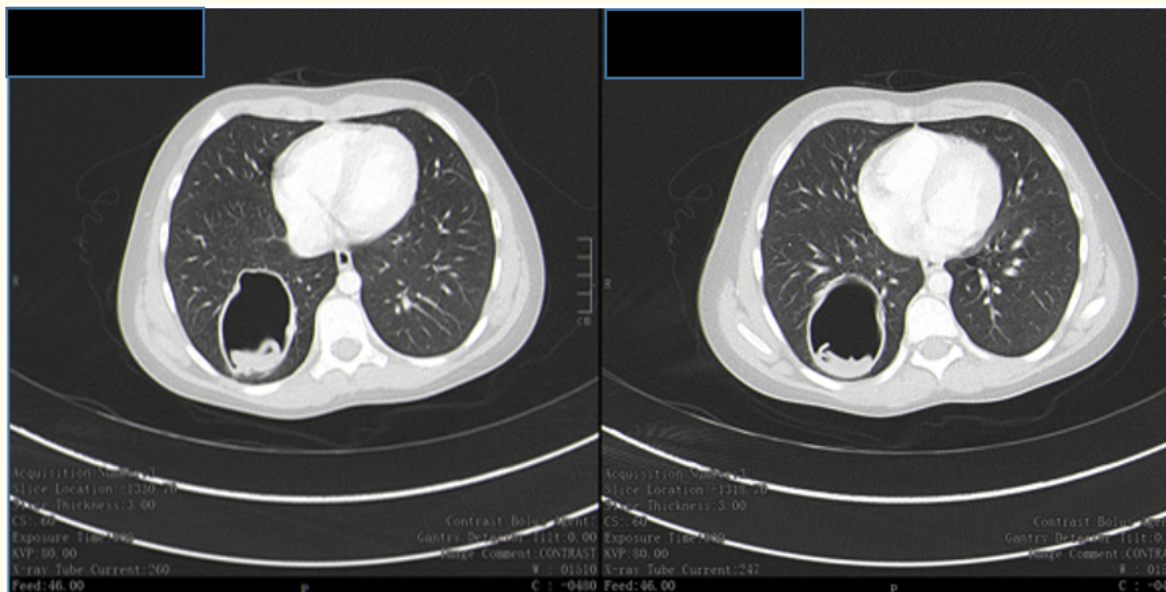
Preoperative Computed tomography of patient 1 showing the hydatid cyst lung.
